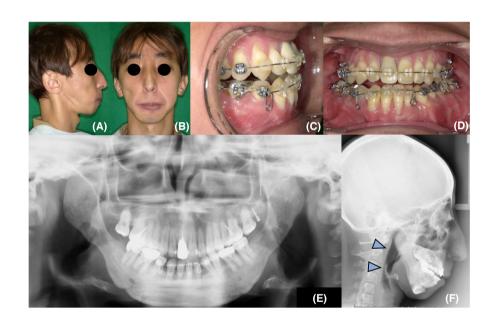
Findings 4 years after distraction. (A, B) Extraoral photographs (facial view): Mandibular retrognathia has been corrected. (C, D): Intraoral photograph: No signs of relapse or change in molar occlusion. (E) Panoramic radiograph: Osteosclerotic lesions are observed. (F) Cephalometric radiograph: Upper airway stenosis has been resolved.
